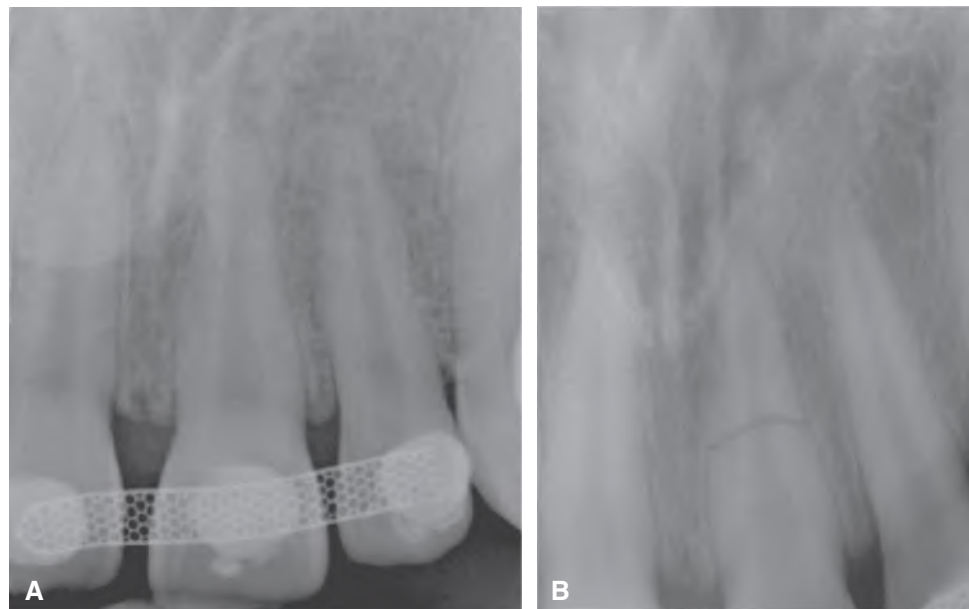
Radiographic technique for finding diagonal root fractures. A. Conventional 90° periapical radiograph of a maxillary central incisor with a diagonal root fracture that is easy to miss since the fracture does not show radiographically. B. A steep occlusal view (approximately 45°) clearly identifies the fracture because the X-ray beam can travel parallel to the fracture in the root. (Courtesy of the Endodontic Clinic, Loma Linda University, School of dentistry, California.)
